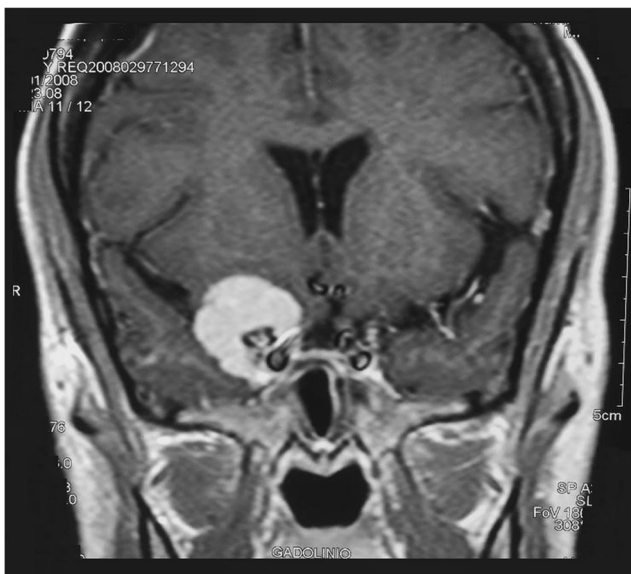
MR enhanced T1-weighted images on coronal view showing clinoidal hyperostosis, site of attachment, distortion of the chiasm, and vicinity of the carotid artery. Note that the cavernous sinus is not occupied by the tumor
